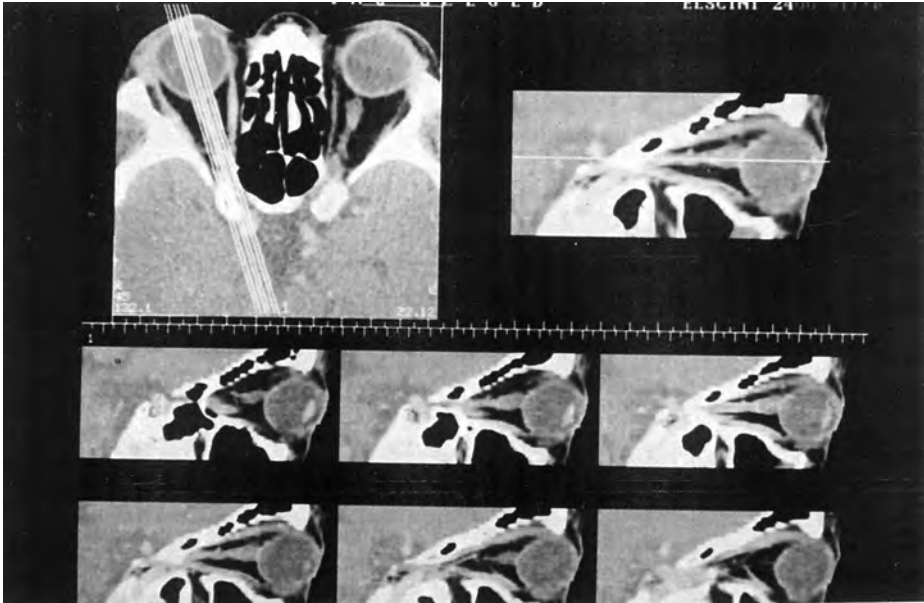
Orbital CT. Thickened, irregular optic sheaths on the right side.
